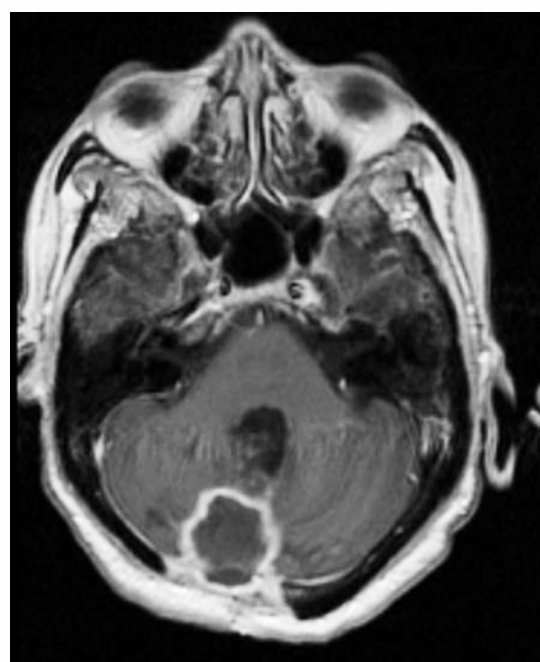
MRI of the brain two years after the removal of recurrent hemangioblastoma
